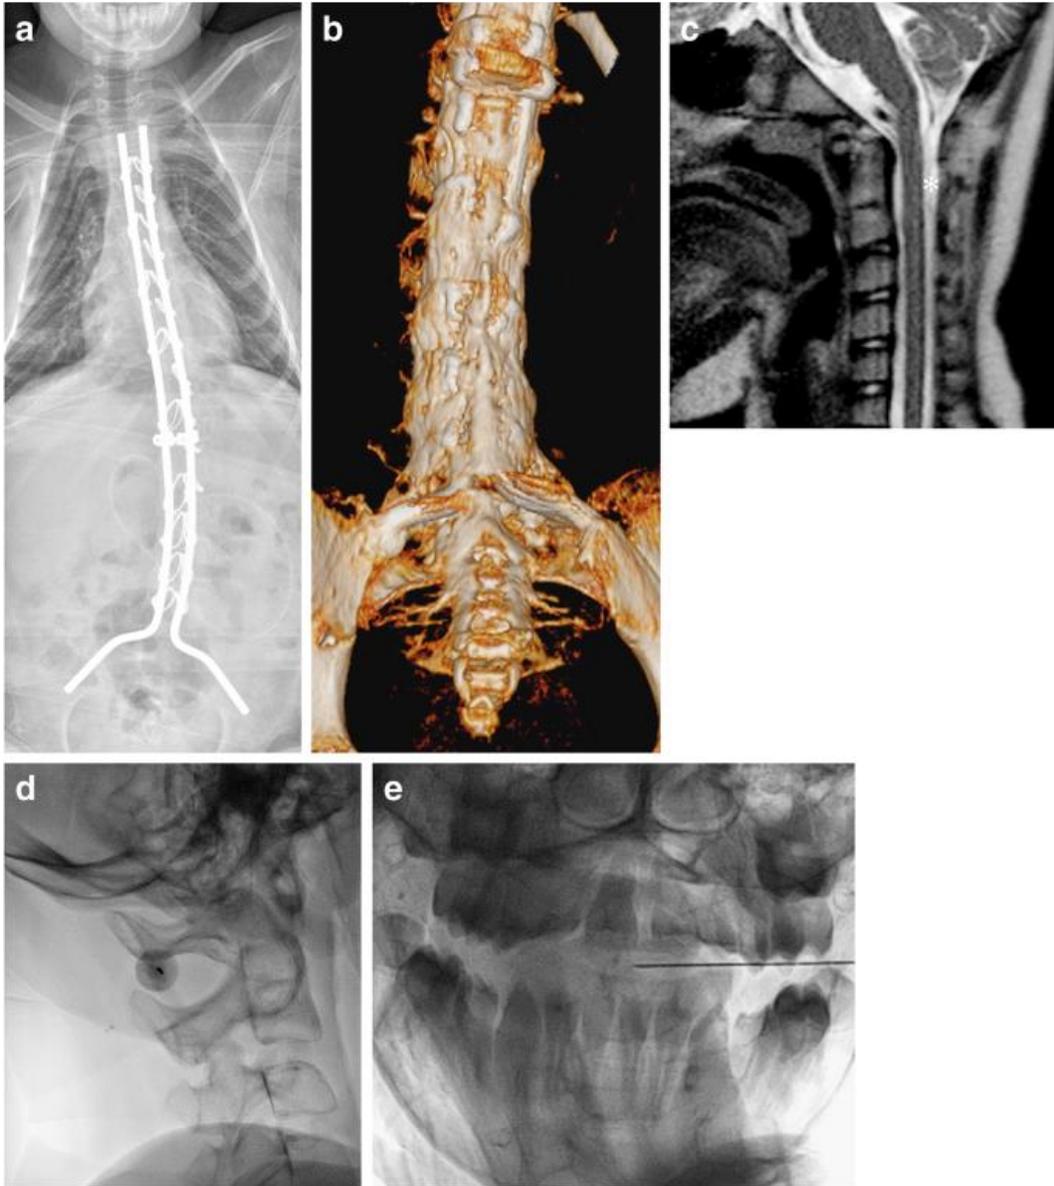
Spinal muscular atrophy type 3 with spinal fusion in a 14-year-old boy. a Anteroposterior thoracolumbar radiograph demonstrates extensive spinal fusion hardware. b Three-dimensional reconstruction from source non-contrast diagnostic lumbar spine CT images demonstrates diffuse bony fusion of the entire lumbar posterior elements. c Sagittal T2-weighted cervical MR clearly demonstrates the cerebrospinal fluid space (*asterisk*) posterior to the spinal cord for cervical puncture. d, e With the boy in lateral decubitus position, lateral fluoroscopic image demonstrates the spinal needle superimposed over the C1-C2 interspace. The orthogonal view is used for monitoring progress of the needle tip position to midline
